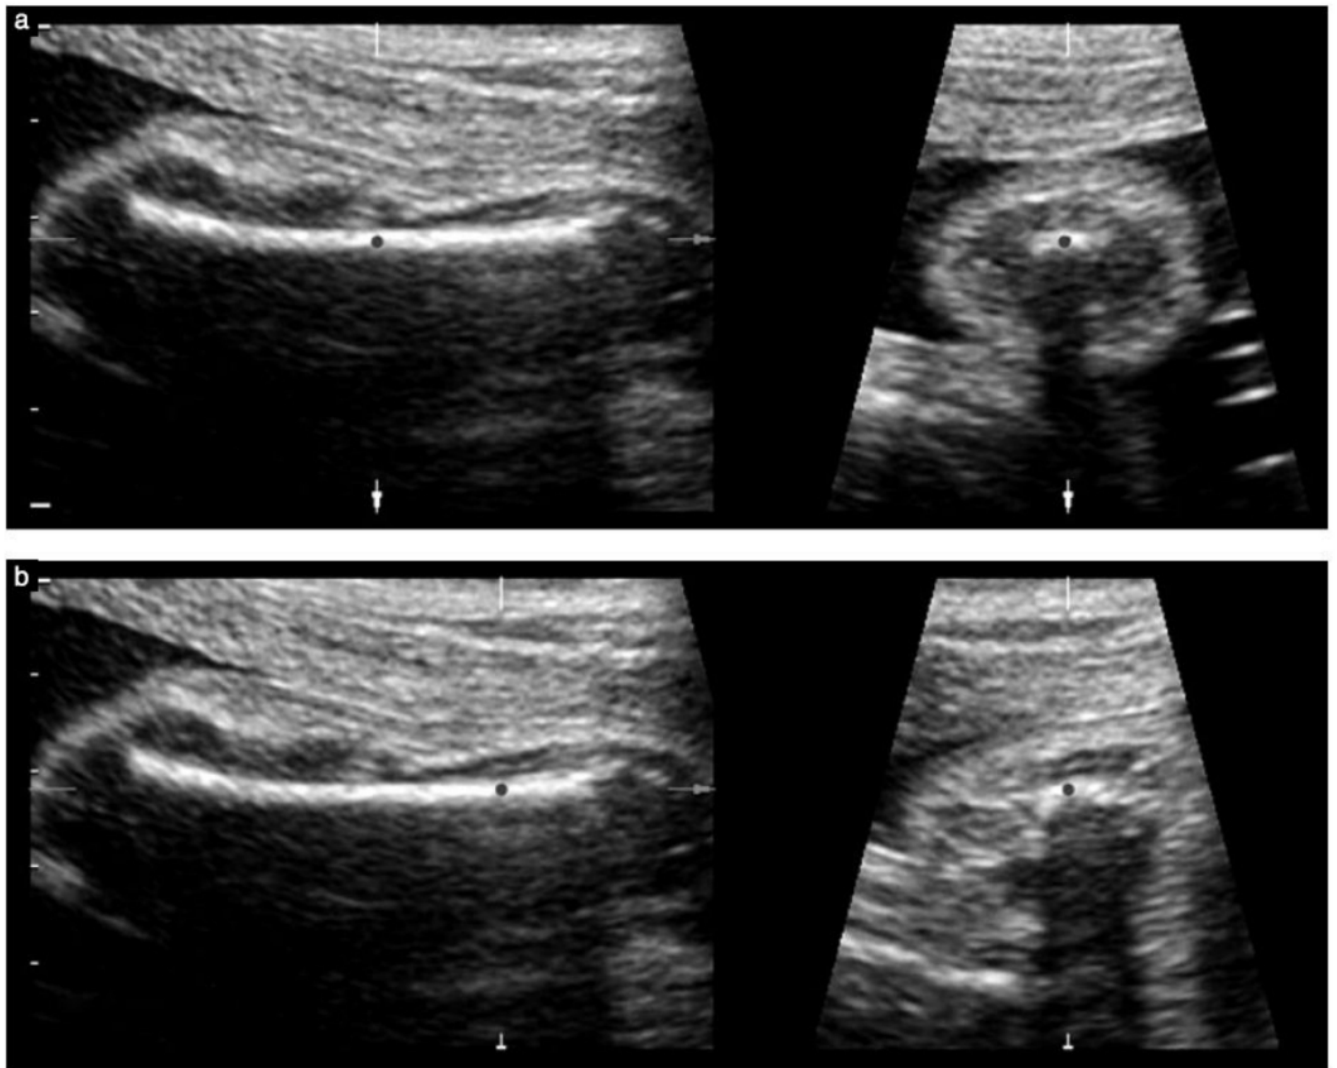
Ultrasound images demonstrating how transverse slices of the mid-limb improves visualization of the soft tissue borders. Sagittal views of the fetal arm are displayed (left) with their corresponding transverse views (right). (a) Placement of the reference dot at the center of the limb enables soft tissue borders to be visualized clearly in the transverse view. (b) When the reference dot is very close to the shoulder, soft tissue borders are no longer clearly discernible in the transverse view.
